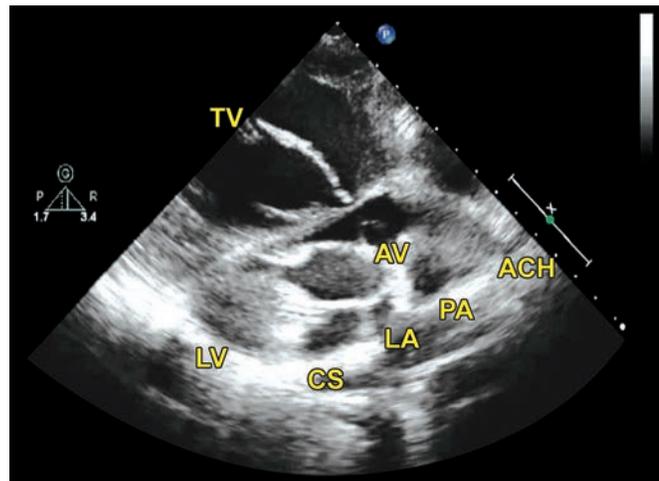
Right parasternal examination. The ascending aorta and arch (ACH) are well imaged.
